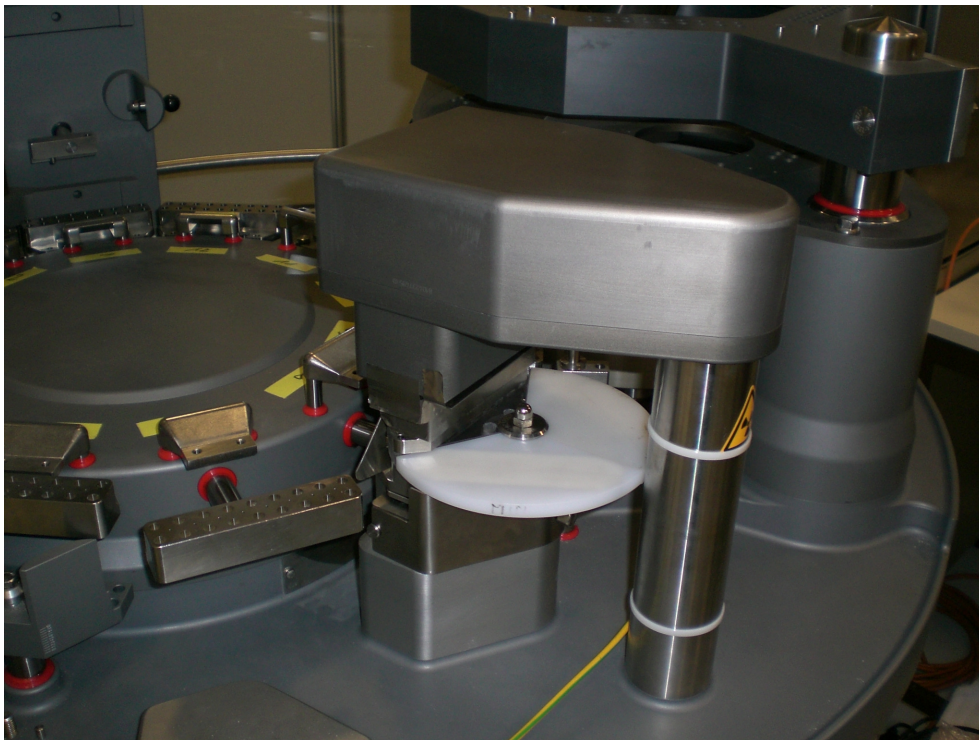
Multi Channel In-line X-Ray Measurement
